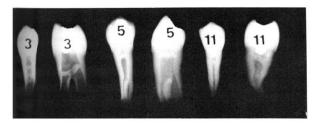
Postextraction radiographs of three different cases showing the hard tissue bridge in mesiodistal and buccolingual views.
